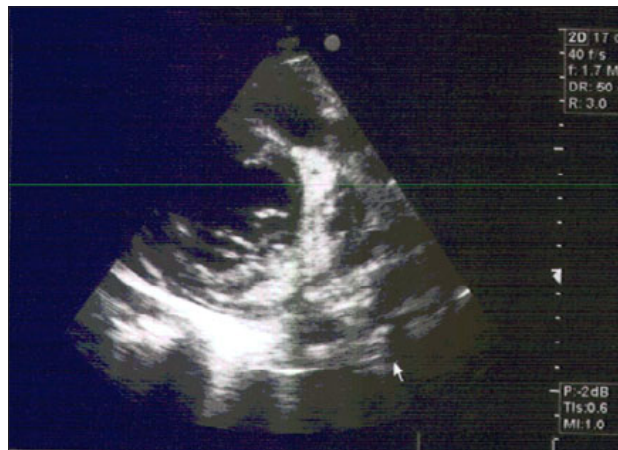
Echocardiography showing infiltrative cardiomyopathy.
